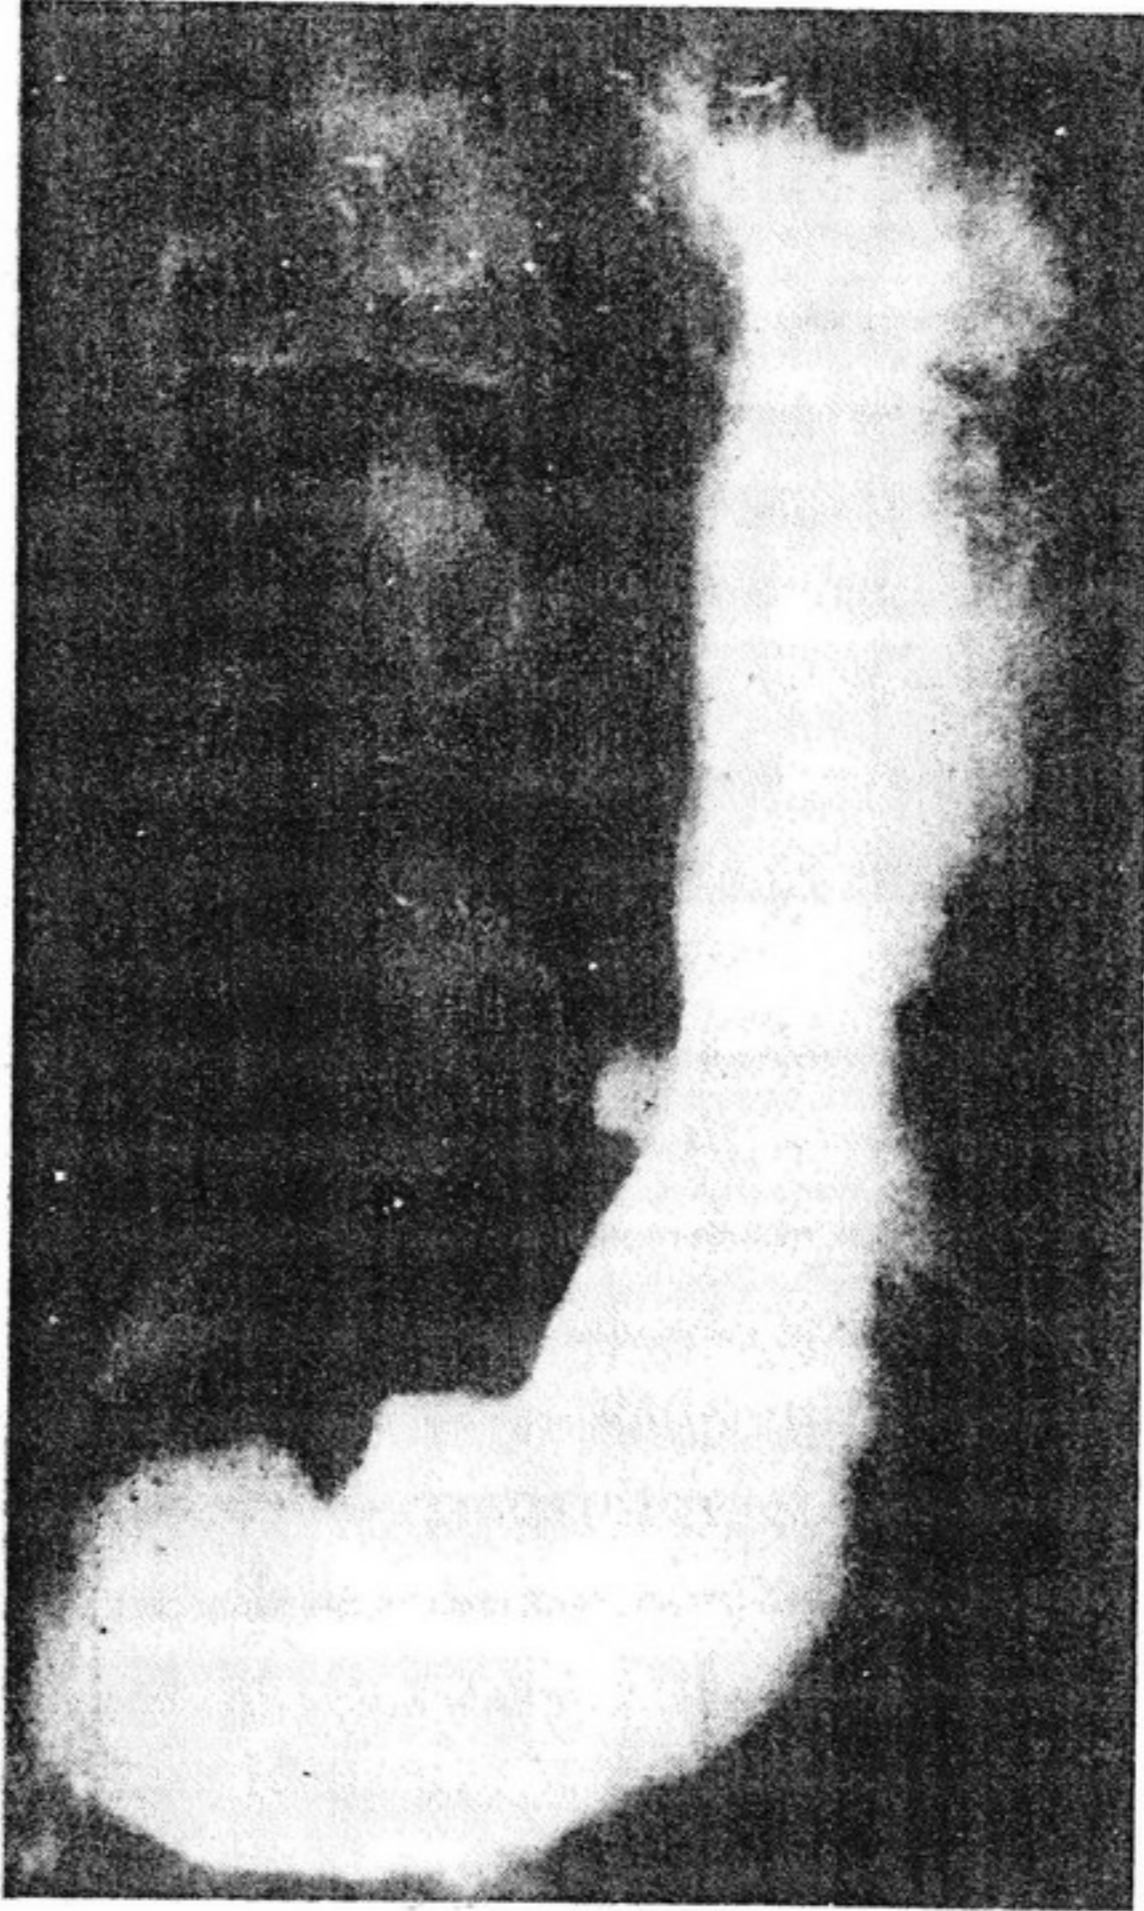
"True" prednisolone ulcer. Early gastric roentgenogram. The ulcer penetrates steeply into the deeper layers as if made by a punch
